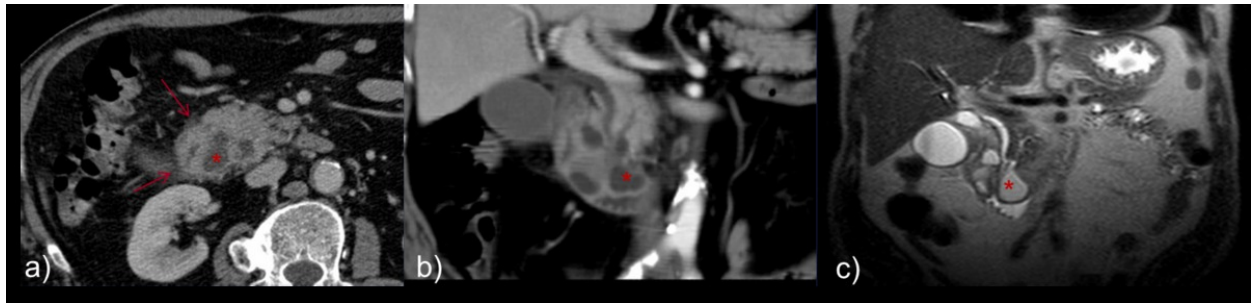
Axial a), coronal b) enhanced CT images and coronal HASTE image c) of a patient with groove pancreatitis presenting with slight duodenal wall thickening (arrows) with discrete luminal stenosis and cystic changes of the duodenal wall (*).
